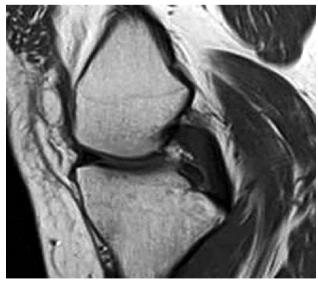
Sagittal T1W MRI image of the same patient in figure 5A, reveals contusion of PCL at femoral attachment.
